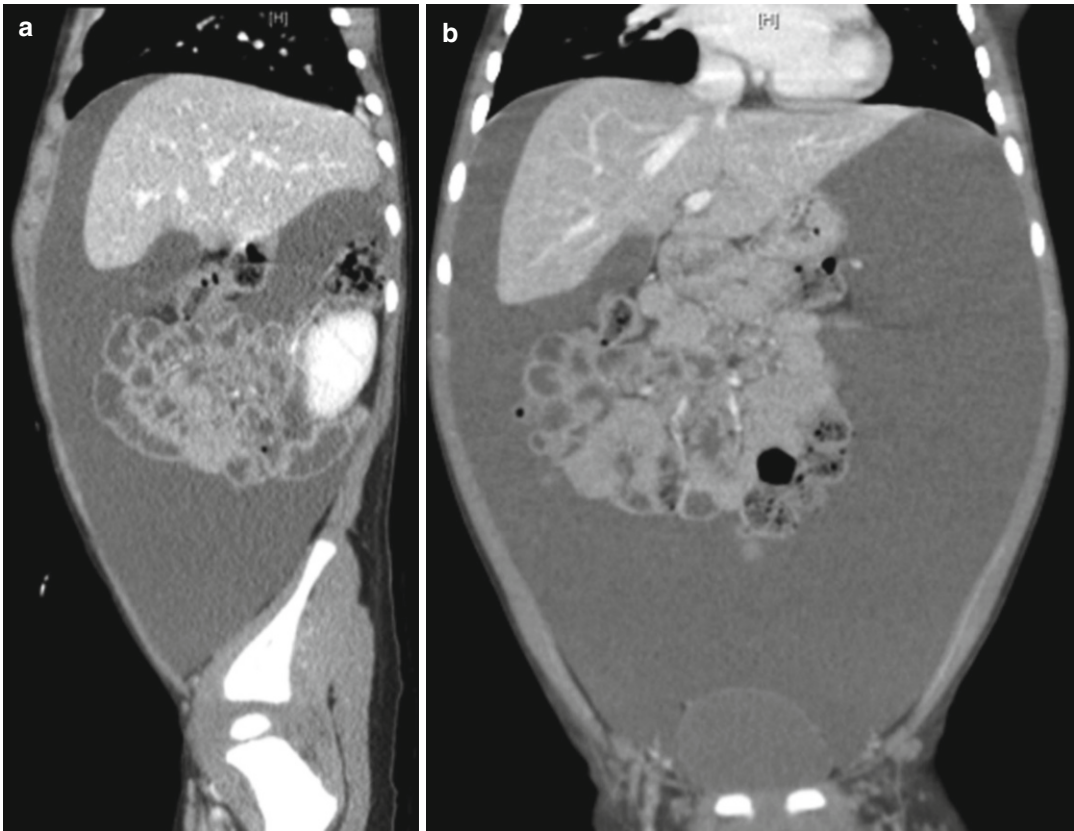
Pseudo-ascites due to giant omental cyst – (a) sagittal and (b) coronal CT views
